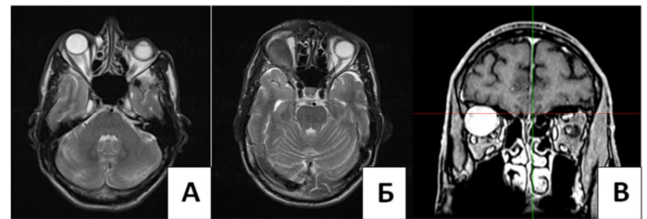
Post-contrast brain MRI images detecting an extensive right-orbit neoplasm.
